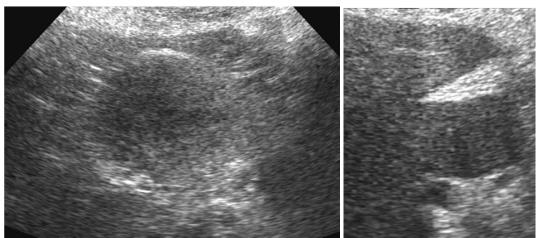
a, b Apparent FL (in CT suspected malignoma) with accessory liver lobe; SCS right (a) and UAS transverse (b)
